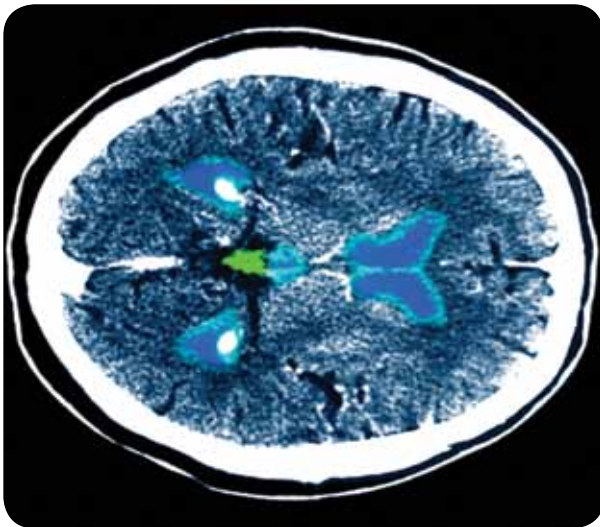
The CT scan at the top is of a normal brain; the CT scan at the bottom shows the area of brain damage in a person who has suffered a stroke.
